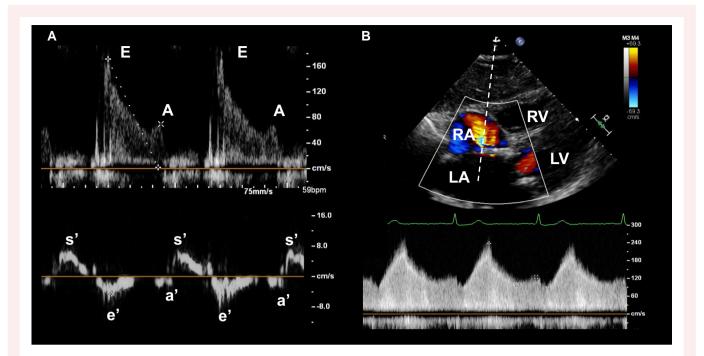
Transthoracic echocardiogram of a 79-year-old woman. Pulsed wave Doppler signal showing significantly enlarged E wave and blunted A wave, resulting in high E/A ratio of 2.40 and the E/e' ratio of 27.4 (A). Subxiphoid view revealed continuous colour flow from the LA to the right atrium (RA). A continuous wave Doppler echocardiography revealed a peak pressure gradient of 23 mmHg, suggesting significantly elevated LA pressure (B). LV, left ventricle; RV, right ventricle.
